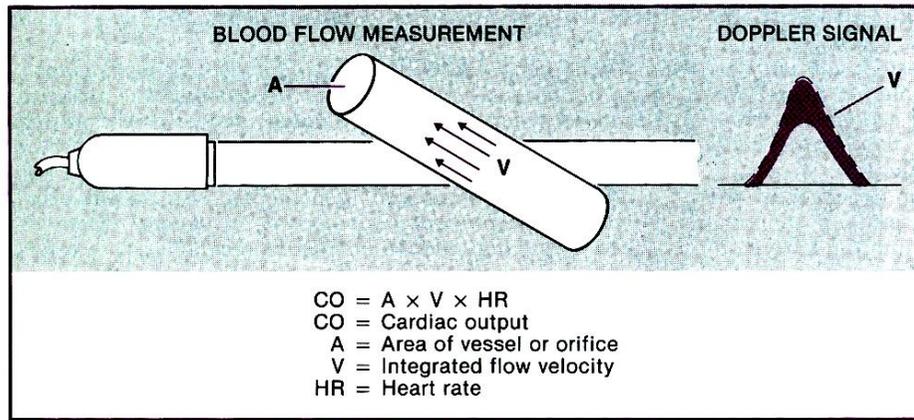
Principles of using Doppler echocardiography to measure blood flow.
